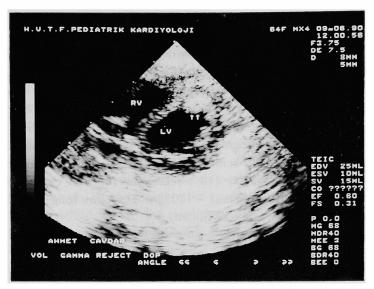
Two-dimensional echocardiogram. Arrows indicate the thrombotic mass in the left ventricular apex. RV=right ventricle; LV=left ventricle.
